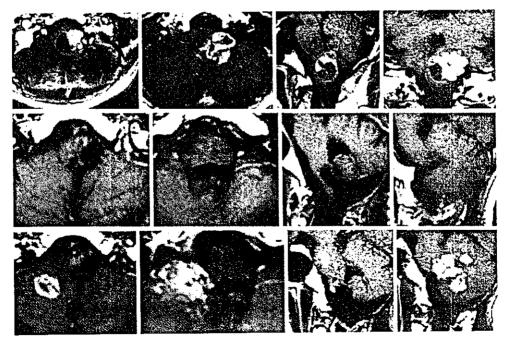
Pre- and postoperative enhanced MR imaging (case 1). Upper: preoperative MR images revealing a heterogeneously enhanced cystic tumor with a relatively clear margin in the medulla oblongata on the left side. Middle: MR images 2 years and 3 months postoperatively showing no tumor recurrence. Lower. MR images 3 years and 5 months postoperatively showing tumor recurrence at a site distant from the tumor-removed cavity.
